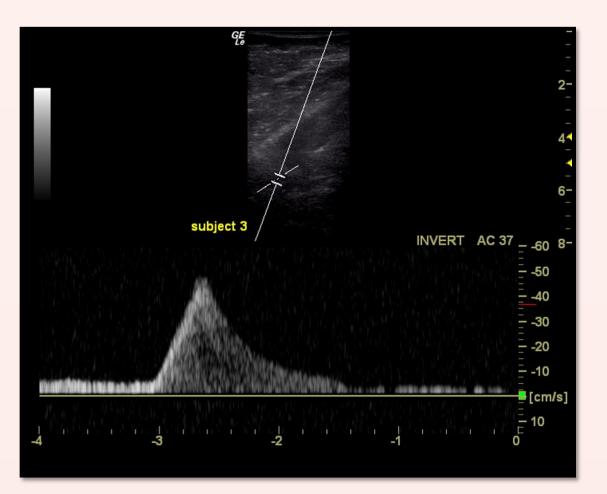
RF Health MAC System Doppler ultrasound blood flow curve
